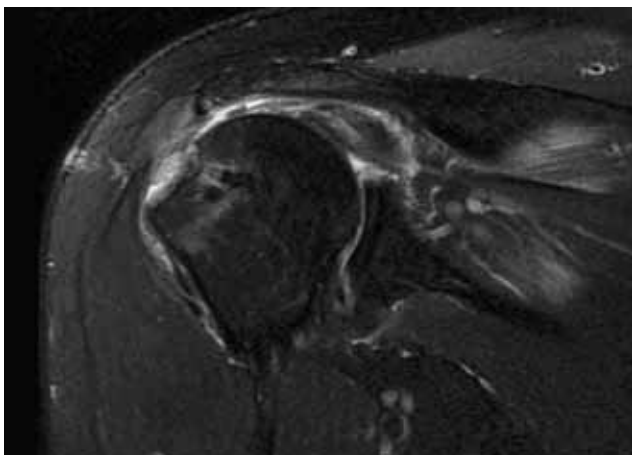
Magnetic resonance imaging of right shoulder 7 weeks after index surgery.
